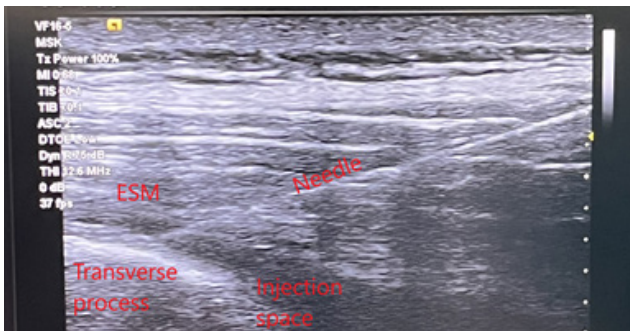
Ultrasound-guided ESB performance at the T4 level
